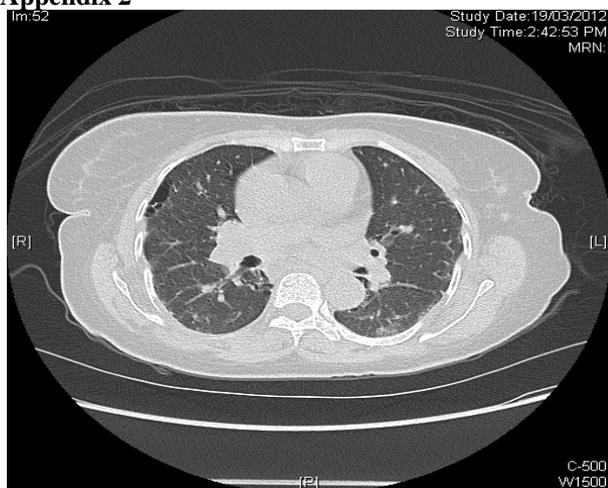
High resolution CT Chest, March 2012 showing bilateral fibrocystic changes lower lobes and cysts in the peripheries.
